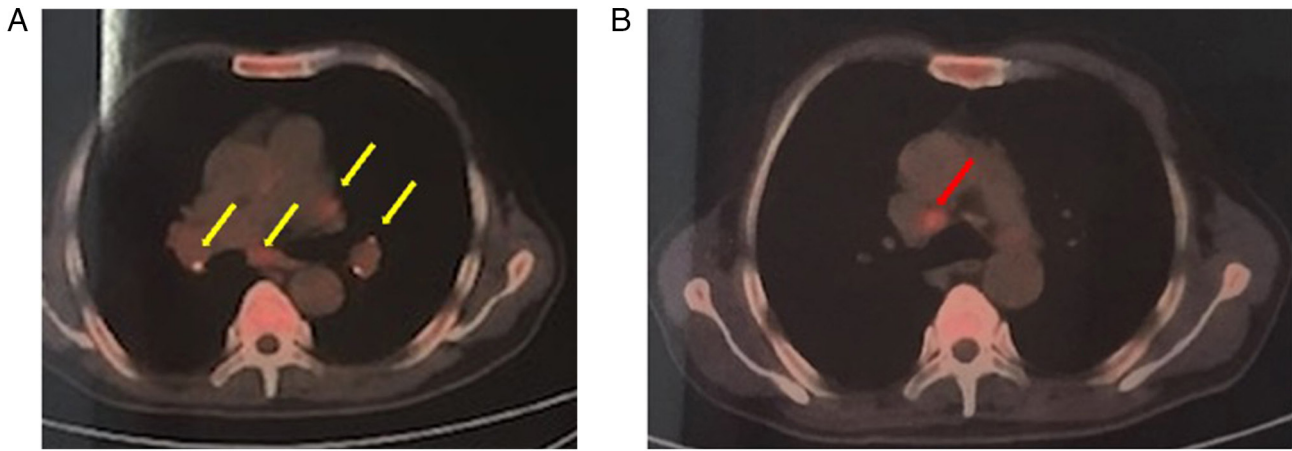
PET-CT image. (A and B) PET-CT images showing multiple lymph nodes in the bilateral mediastinum, lungs and liver hilum. (A) FDG metabolism is unevenly increased (indicated by the yellow arrows) and (B) the maximum standardized uptake value is ~ 4.3 (indicated by the red arrow). No significant abnormal increase in FDG metabolism was observed in the rest of the body. PET-CT, positron emission tomography-computed tomography; FDG, fluorodeoxyglucose.
